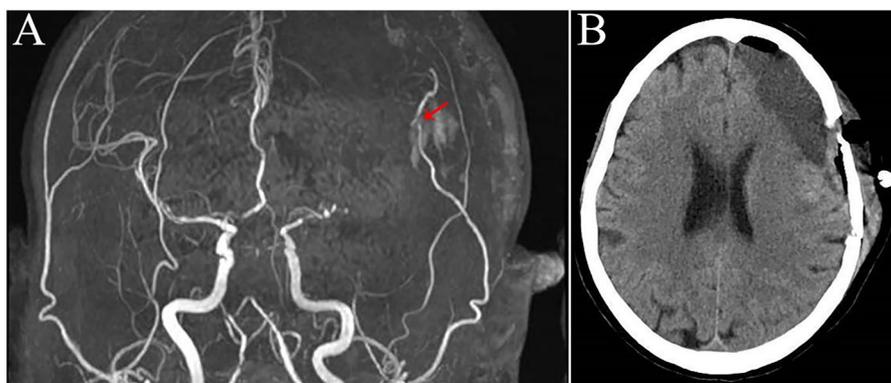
(A) MRA showing the patency of left STA-MCA bypass 2 days after surgery (arrow). (B) CT 2 days after surgery showing low-density lesion at left frontotemporal lobes without subdural hematoma. CT, computerized tomography; MRA, magnetic resonance angiography; STA-MCA, superficial temporal artery–middle cerebral artery.
